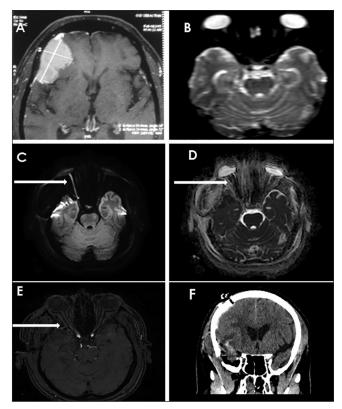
Panel A. Preoperative MRI showing a right pterional meningioma. Panel B shows a preoperative DWMRI with normal optic nerves. Panel C. DWMRI showing diffusion restriction in the right ON. Panel D. ADC images showing reduced ADC in the right ON. Panel E. MRI MIP images showing a patent's right ophthalmic artery. Panel F. Postoperative CT showing minimal postoperative changes
